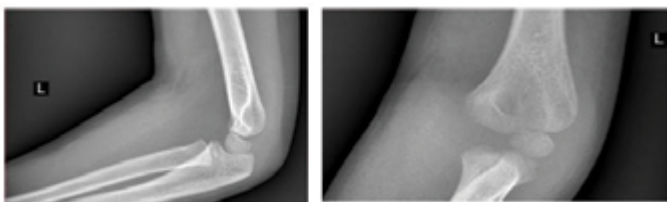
a- initial radiographs, b-admission to the hospital radiographs.
